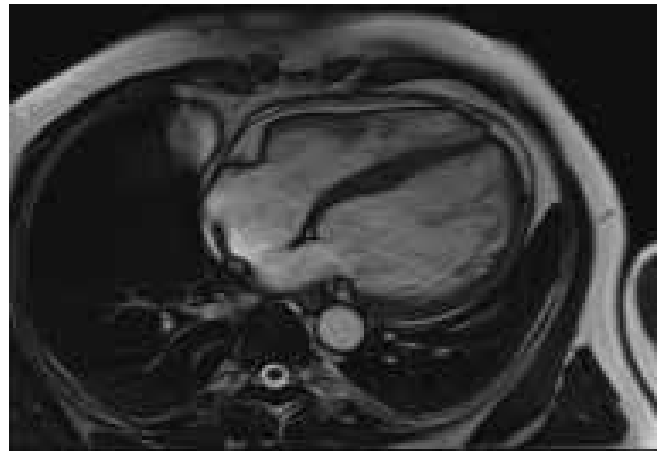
MRI image showing pericarditis
